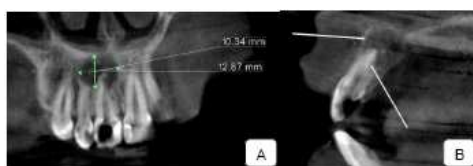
A. CBCT Interpretation (coronal view) show the size of periapical lesion (10,34mm x 12,87mm) and the apex was open. B. CBCT Interpretation (axial view) show that palatal and labial bone was resorbed and thin.
